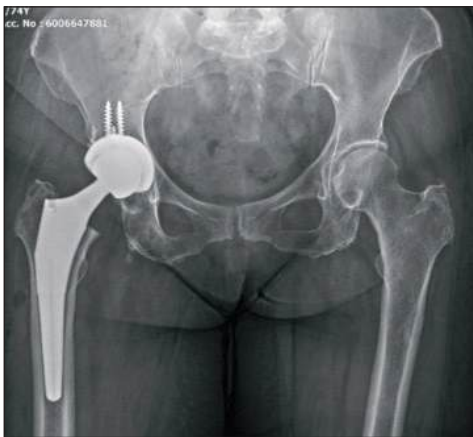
Anteroposterior pelvic radiography showing right total hip arthroplasty.
